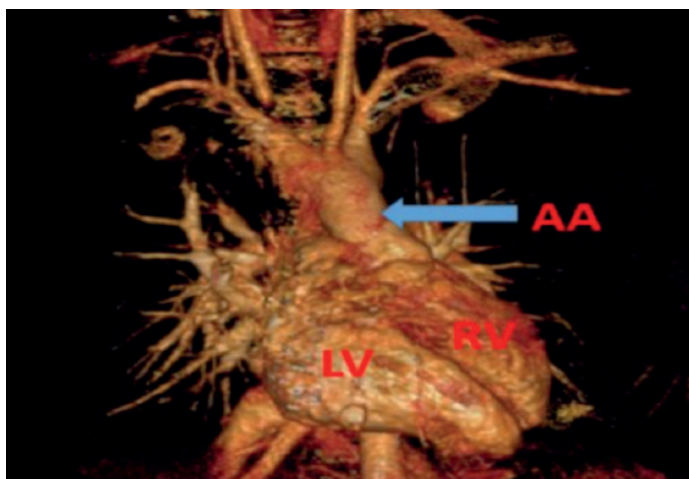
Three-dimensional reconstruct of patient's congenitally corrected transposition of the great arteries anatomy by high resolution computed tomography with anterior view. AA , ascending aorta; RV, right ventricle; LV , left ventricle
